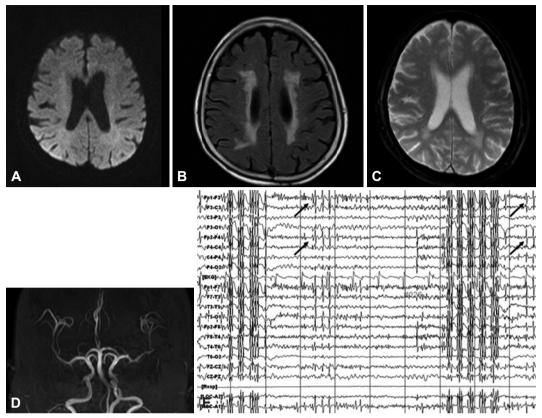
Diffusion-weighted imaging (A) revealed no acute lesion and FLAIR imaging (B) revealed bilateral ischemic lesions in the subcortical areas. Gradient echo imaging (C) and MRA (D) revealed no specific abnormality. EEG showed abundant bursts of high-voltage generalized polyspikes with a normal background. Some isolated interictal spikes (arrows) were evident between or preceding the bursts (E). EEG: electroencephalogram, FLAIR: fluidattenuated inversion recovery, MRA: magnetic resonance angiography.
